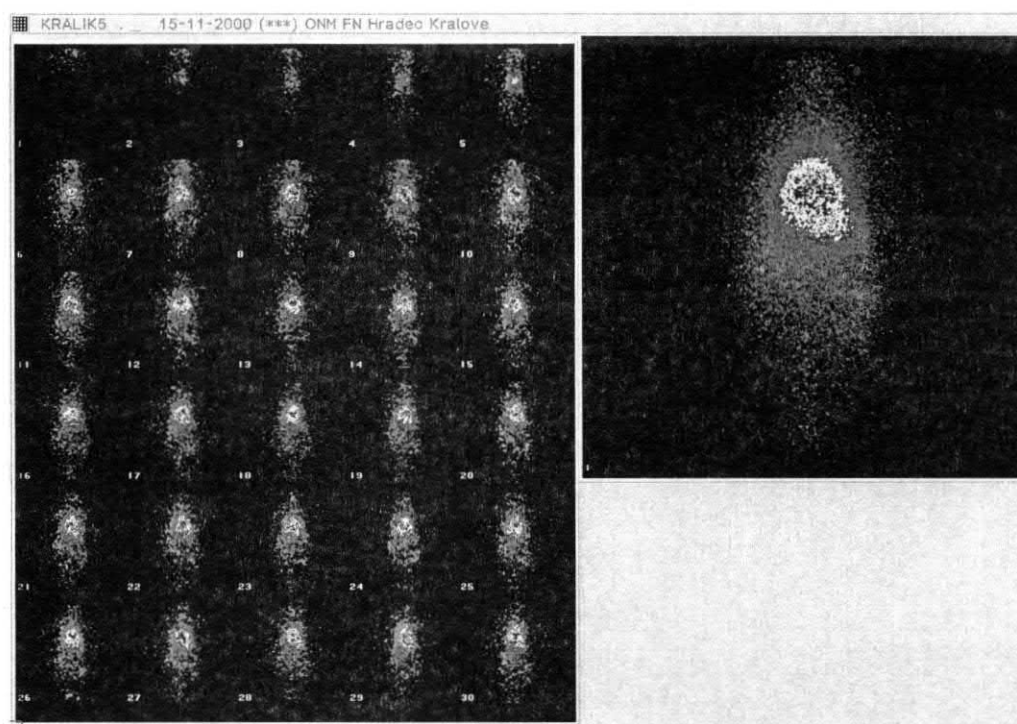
^{131}I -lipiodol administered into the jugular vein (dynamic scintigraphy 0–5 min. pictures no. 1–30, static mode 5.–12. min - see right big picture)
